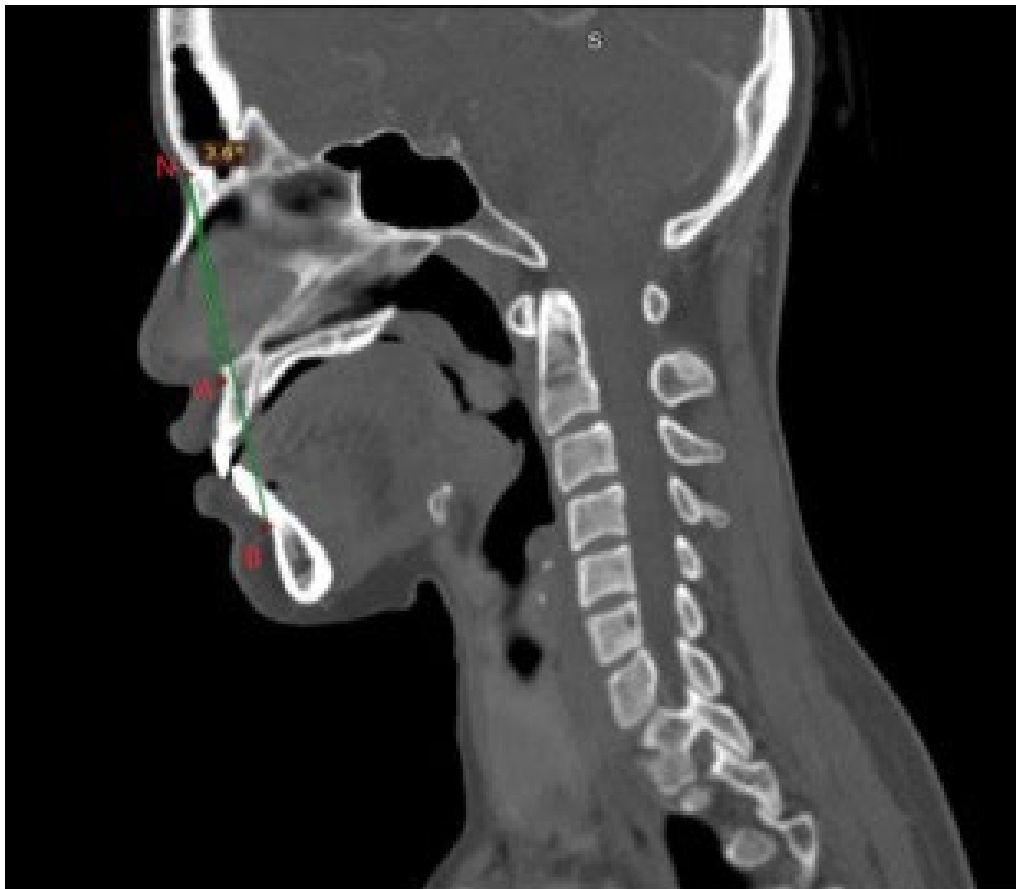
CT image showing ANB angle used for skeletal classification into Class I, II and II.
